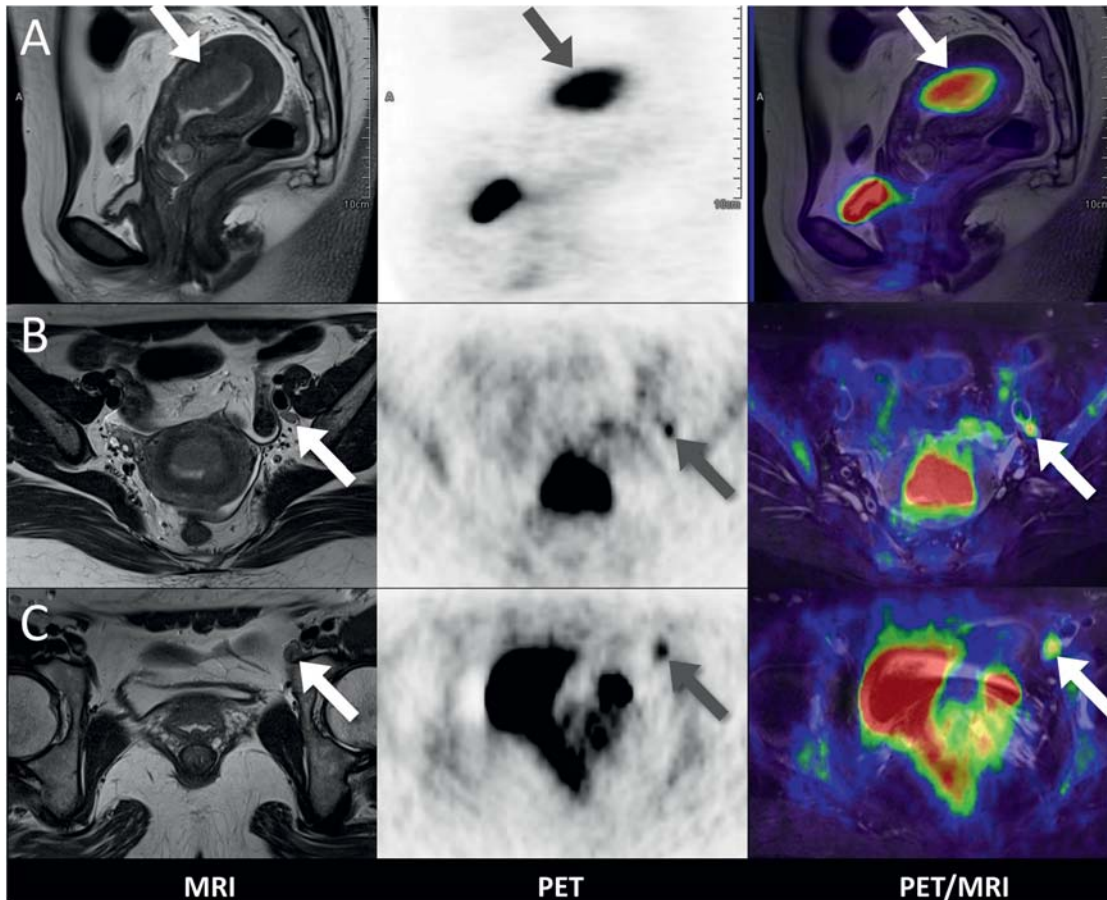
A 40-year-old woman with endometrial cancer, endometrioid adenocarcinoma, with small left iliac lymphadenopathy, stage IIIc1. (A) MRI, PET, and PET/MRI showing a hypermetabolic tumor (arrows) in the uterine cavity ($SUV_{max} = 25.2$). The other hot-spot in the anterior pelvic cavity is the urinary bladder. (B, C) Two small lymph nodes (<1 cm) in the left external iliac region (arrows), which were not suggestive of metastasis by size criteria on MRI alone. However, high FDG uptake was noted on PET images, suggesting metastasis. Surgical pathology confirmed lymph node metastasis.
